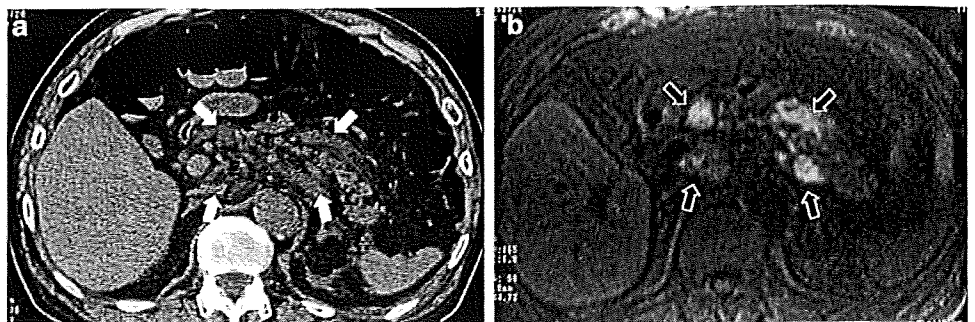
Plain CT shows gas image caused by infection with gas-forming bacteria, in and around the pancreas
